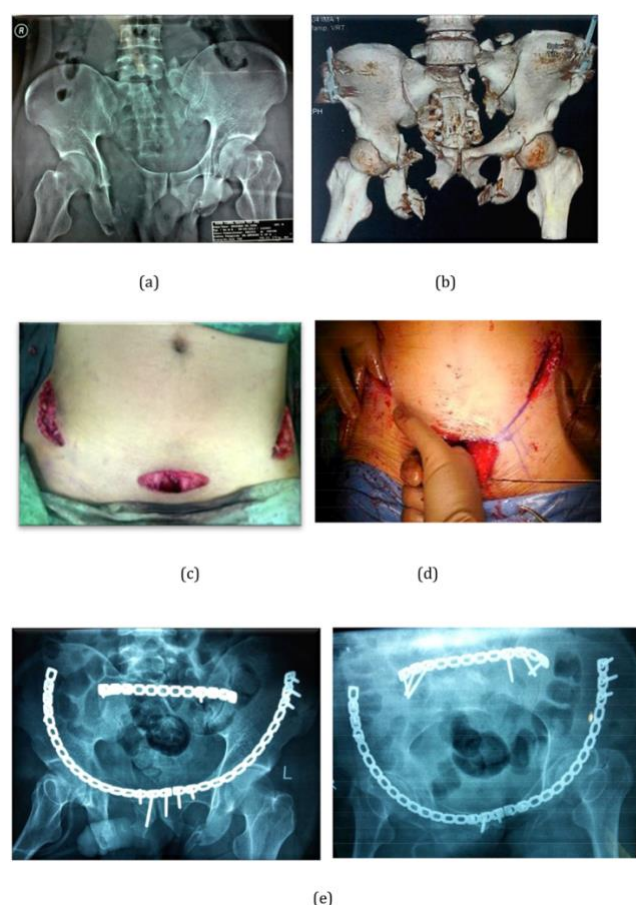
A 36 years old male with unstable pelvic fracture, MT C3 Type right anterior column (a) Preoperative anteroposterior pelvic radiograph showing fracture of right superior and inferior pubic
